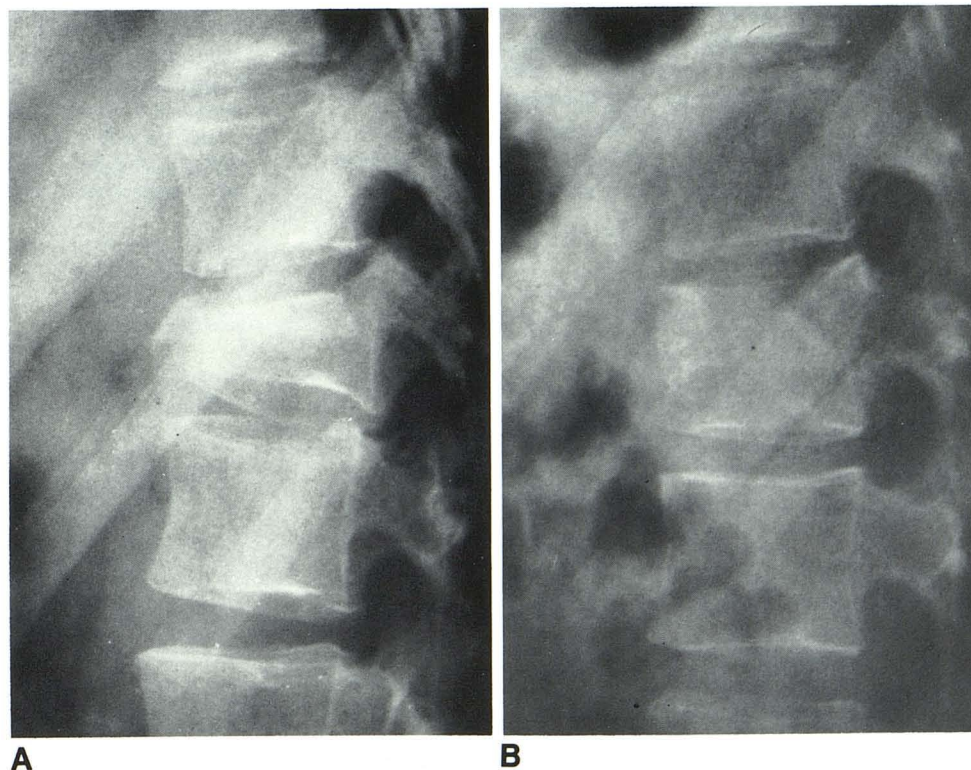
A, Initial radiograph. Compression fracture of L1 vertebra. B, 8 months after surgery. Satisfactory alignment and reformation of vertebral body.
